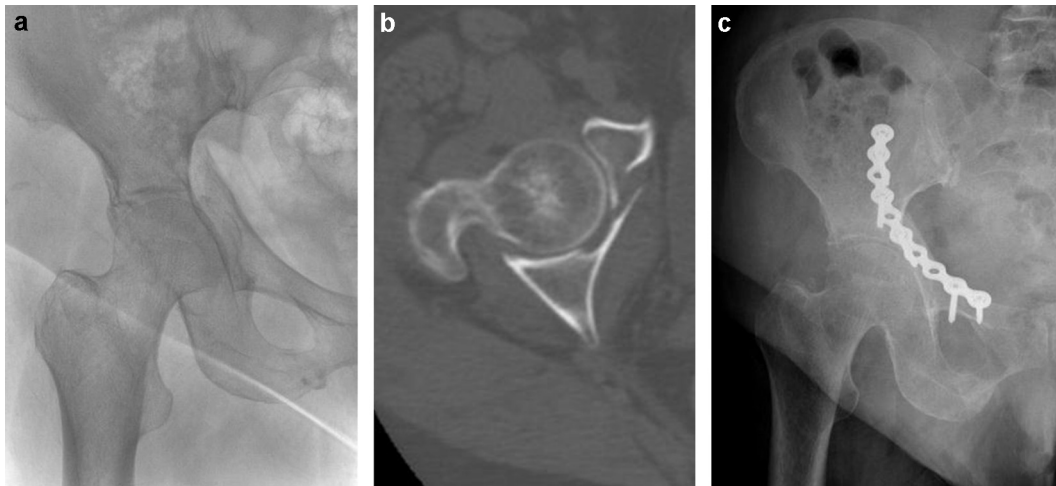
a and b: preoperative radiograph and CT-scan of a patient undergoing the ilioinguinal approach to treat an anterior column fracture. c: postoperative radiograph showing adequate reduction.
